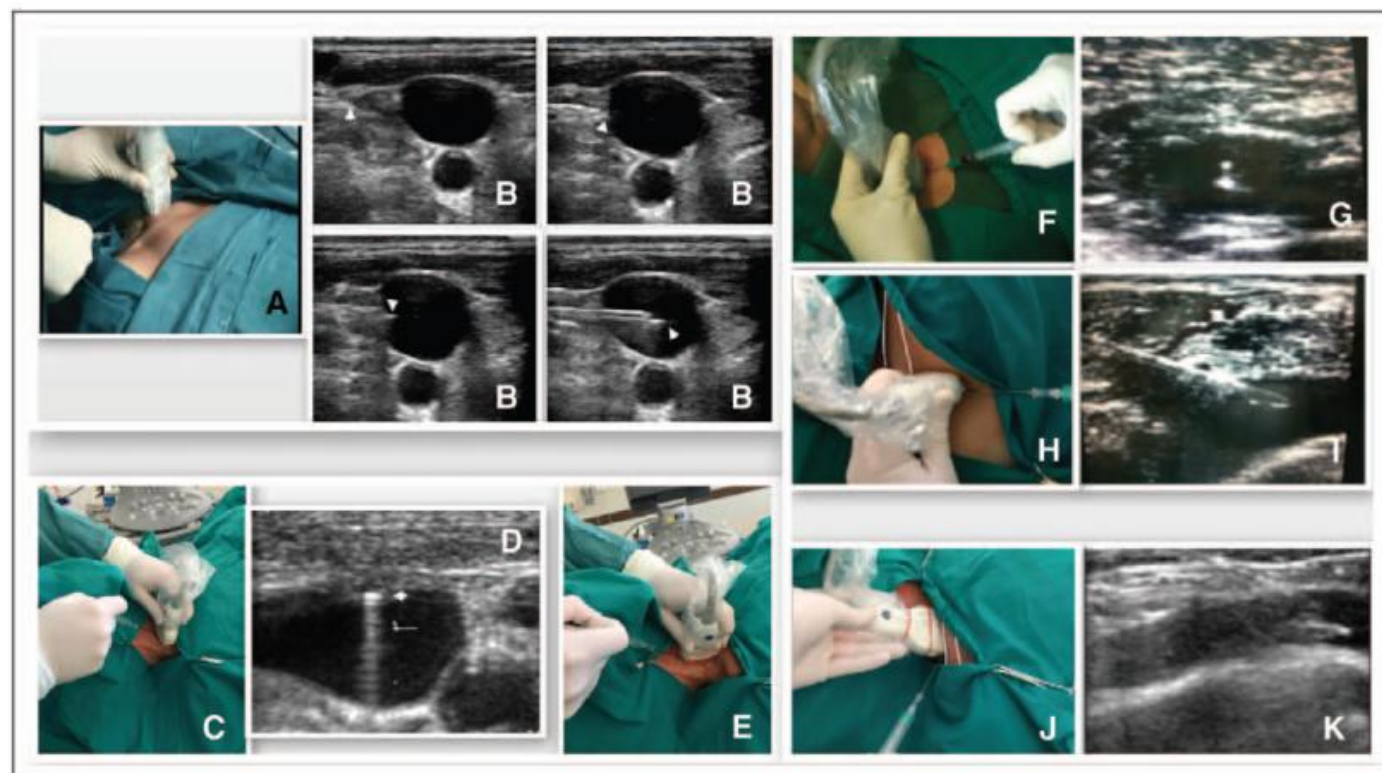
Ultrasound-guided venipuncture techniques. A–E, Ultrasound-guided puncture techniques of the internal jugular vein (IJV): in-plane (IP) puncture performed placing the probe perpendicular to the long axis (LA) of the IJV so to obtain a short-axis (SA) view of the target vessel and advancing the needle in a plane aligned with the LA of the probe, within the ultrasound beam (A); needle tip (*white arrowheads*) approaching and entering the target vein during real-time ultrasound-guided IP puncture of IJV visualized in its SA (B); out-of-plane (OP) puncture performed placing the probe perpendicular to the LA of the IJV so to obtain an SA view of the vein and advancing the needle in a plane perpendicular to the LA of the probe (C); needle tip visualized as a hyperechoic point entering the target vein during real-time ultrasound-guided OP puncture of IJV visualized in its SA (this approach is not recommended as first choice) (D); and IP puncture performed placing the probe parallel to the LA of the IJV so to obtain an LA view of the target vessel and advancing the needle in a plane aligned with the LA of the probe (E): this approach is absolutely not recommended and it must be avoided for the reasons explained in the text. F–I, Ultrasound-guided puncture techniques of the axillary vein: OP puncture performed advancing the needle perpendicular to the LA of the probe (F); needle tip visualized as hyperechoic spot into the target vessel, both needle tip and AV are visualized in their SA (G); IP puncture of the AV visualized in its LA advancing the needle within the LA of the probe (clavicula borders are highlighted by *white lines*) (H); and needle tip and shaft entering the AV, both are visualized in their LA (I). J and K, Ultrasound-guided puncture technique of the subclavian vein (ScV): IP puncture of the supraclavicular area (clavicula borders are highlighted by *white lines*) (L) and needle tip and shaft entering the ScV (M).
